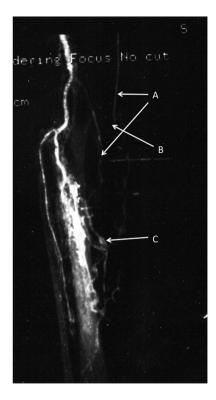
Three-dimensional enhanced computed tomography angiography of the right leg. Arrow A indicates the residual great saphenous vein, arrow B indicates the part of the vein ligated during the initial surgery, and arrow C indicates the recurrent varicose lesion that ruptured.
